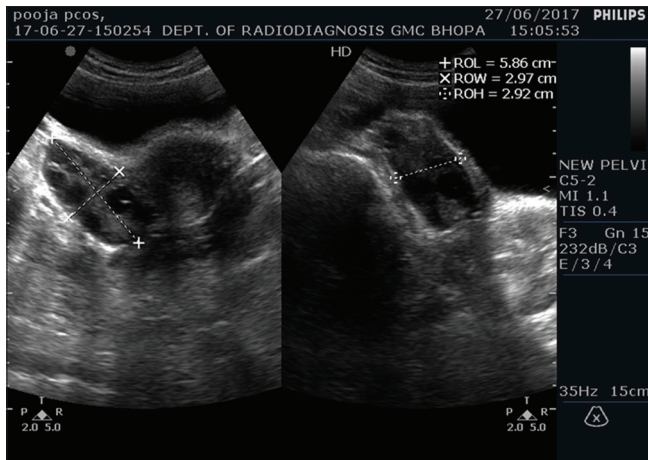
Grayscale ultrasound showing ovarian volume measurement, bulky ovary, and multiple peripherally arranged follicles with echogenic stroma
